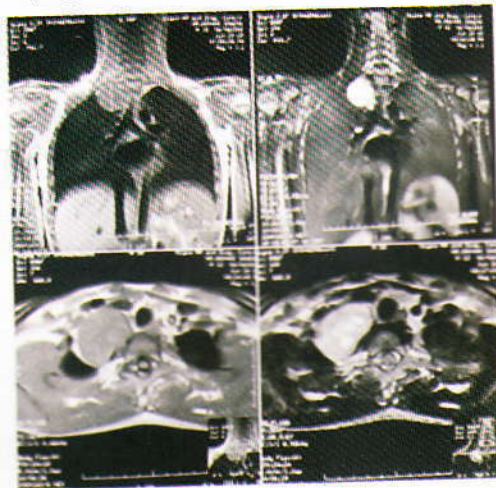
MRI thorax showing a large 4.8 x 4.6 x 4.4 cm mass in right paraspinal area (D1-D3), in the apical region close to trachea and main vessels.
